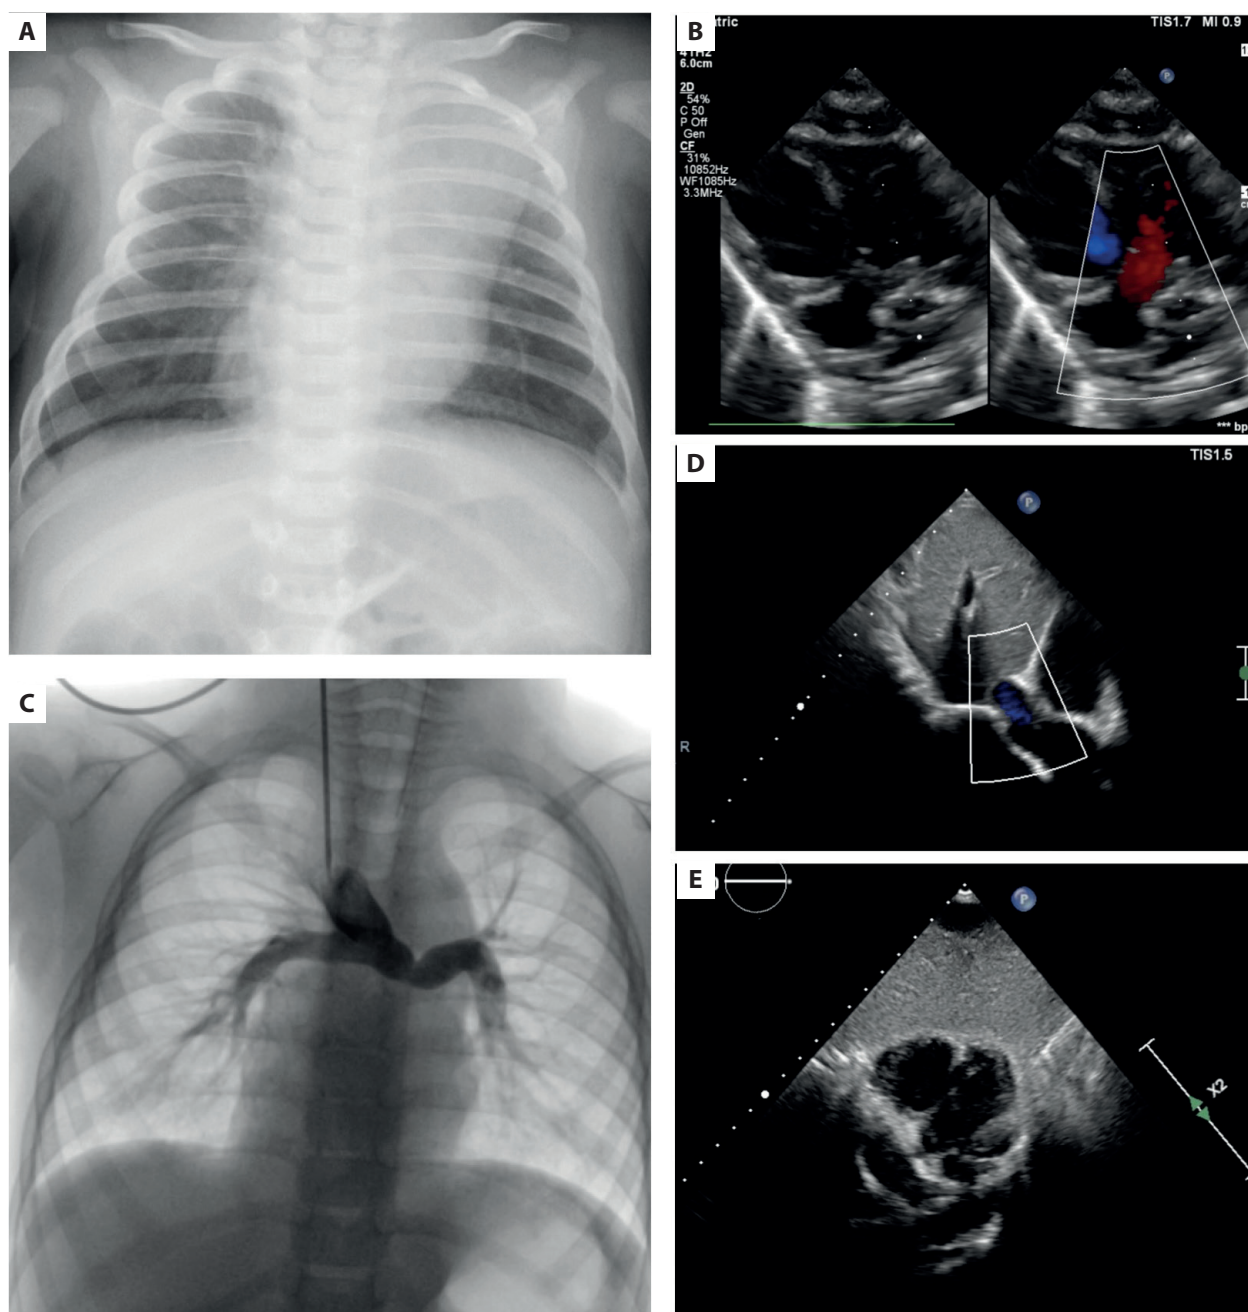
A. Chest X-ray (neonate period) — heart located medially, heart apex facing right. B. Echocardiography (neonate period) of the criss-cross heart morphology — cross-flow and abnormal AV connections — more in Supplementary materials, *Video S1*. C. Heart catheterization after the bidirectional Glenn procedure at the age of 6 months. D. Echocardiography after Fontan (TCPC) operation — more in Supplementary materials, *Video S2*. E. Control echocardiography at the age of 4 years old — good function of the functionally univentricular heart, effective Fontan flow with respiratory-dependent variability — more in Supplementary materials, *Video S3*
